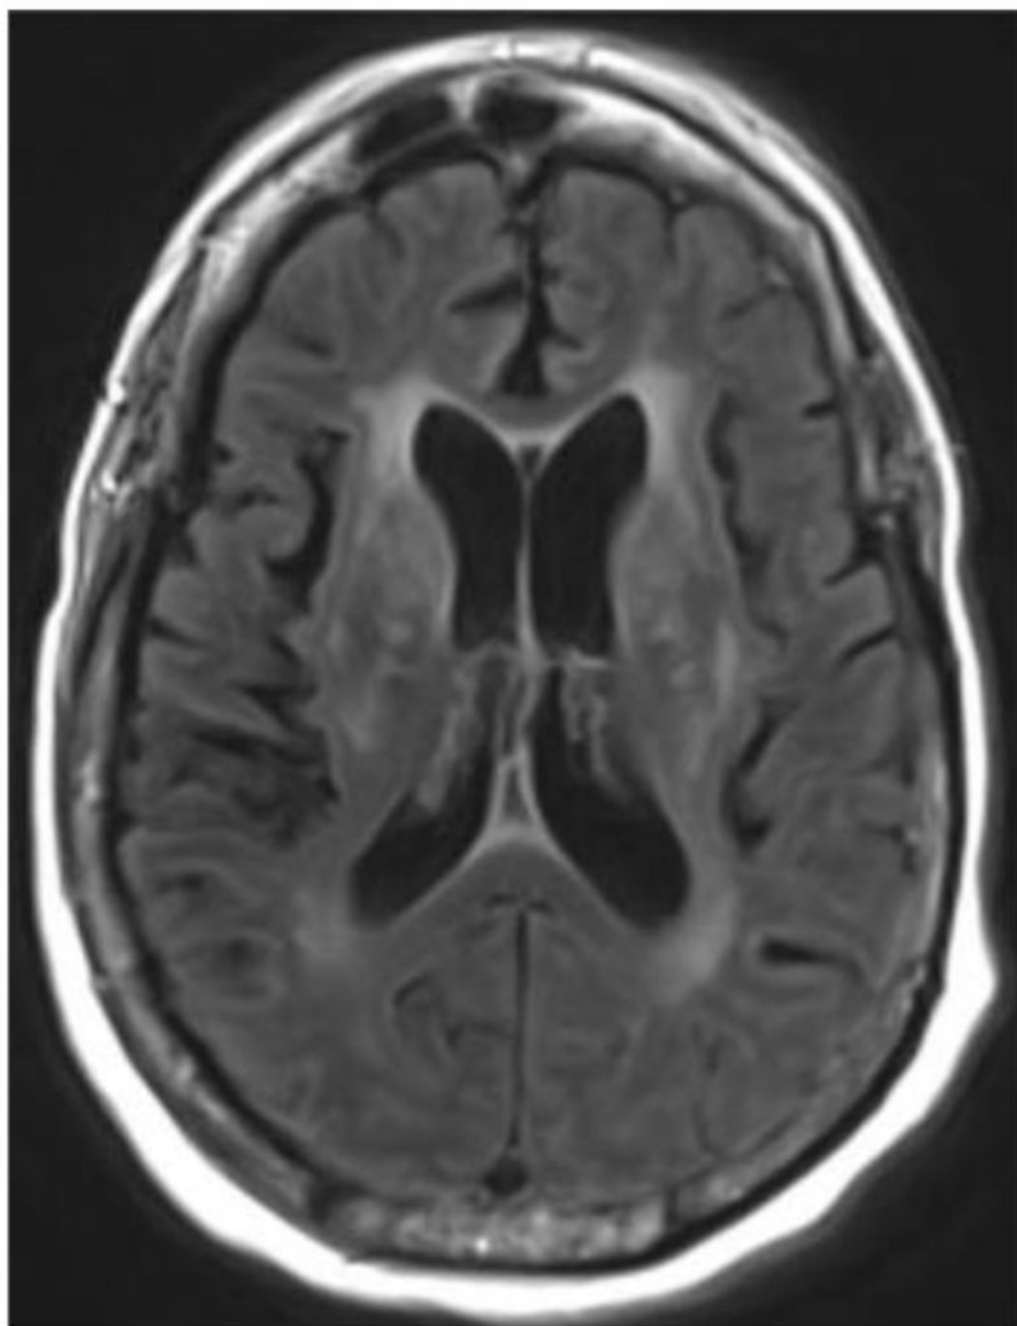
Index kidney recipient MRI brain with and without contrast four months post-transplantation
